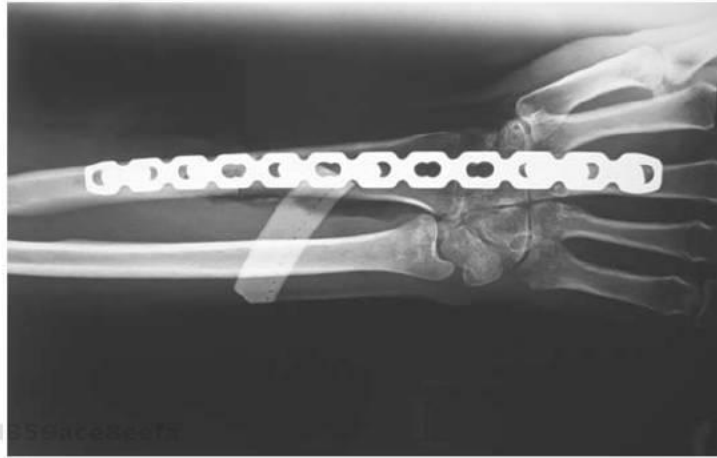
(continued) Treatment of a deformity from a massive collapsed bone allograft and tumor relapse. (a) View showing deformity. (b) Side view of deformity also showing radio-dermatitis around the surgical scar. (c) Lateral radiograph showing the postirradiated fractured massive bone allograft; wrist deformation with subluxation. (d) Lateral radiograph showing the postirradiated fractured massive bone allograft; wrist deformation with subluxation metallic artifact is shown. (e) MRI shows the relapsed tumor. The massive collapse bone allograft is underneath the DCP plate. (f) MRI of an axial slice showing relapsed tumor with a hyper intense area and a hypo intense area due to a metallic artifact. (g) Distal radius massive bone allograft with a reconstruction LCP plate for fusion of the wrist used to replace the fractured bone allograft. Courtesy of Carlos Cuervo-Lozano, M.D.
